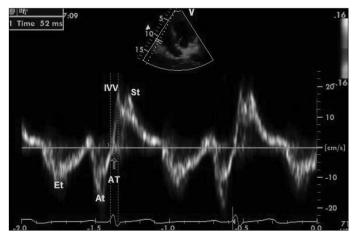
Records of tissue Doppler and calculation of right ventricular IVA. At- late diastolic myocardial velocity, AT - isovolumic acceleration time; Et - early diastolic myocardial velocity; IVCT - isovolumetric contraction time; IVV - peak myocardial speed during isovolumic contraction; ST - systolic myocardial velocity. IVA=IVV/AT
